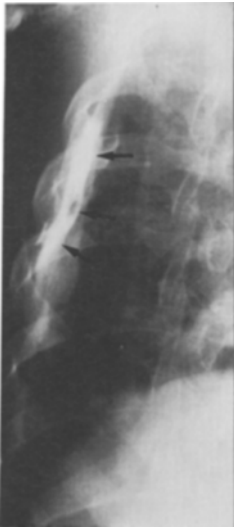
Lateral chest radiograph of the same subject as in figure 4, showing the contrast medium is in the extrapleural space (arrowheads).
